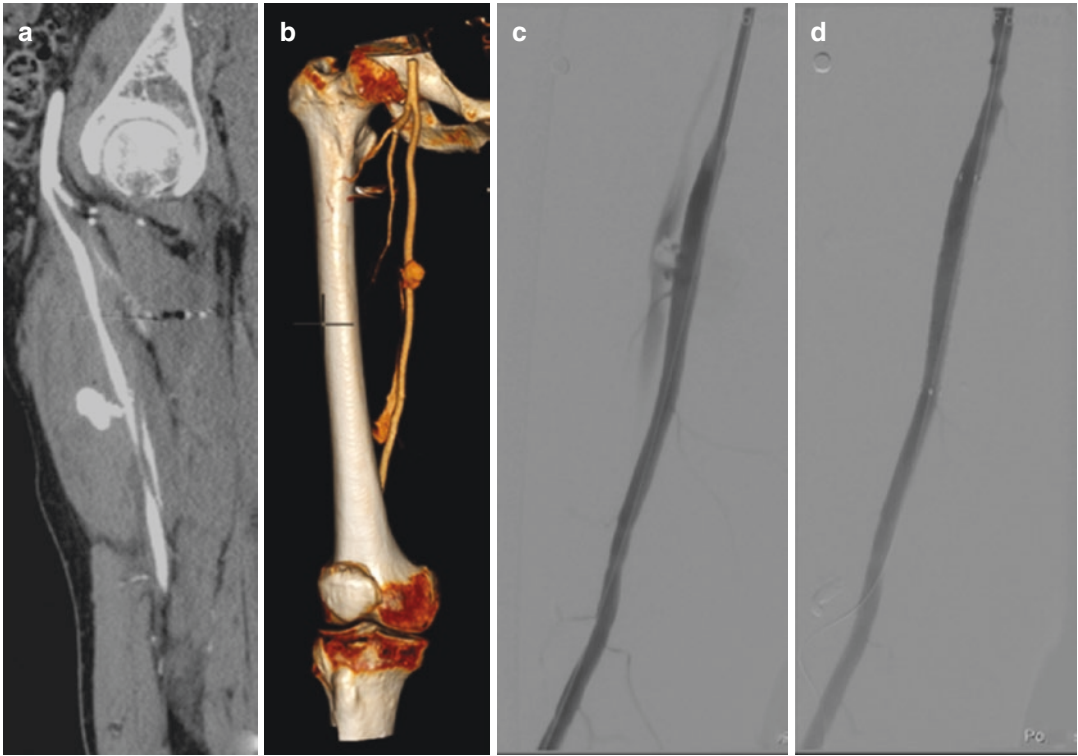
PSA and dissection of superficial femoral artery caused by a gunshot (a); VR reconstruction confirmed findings (b); angiogram reveals findings of CTA
